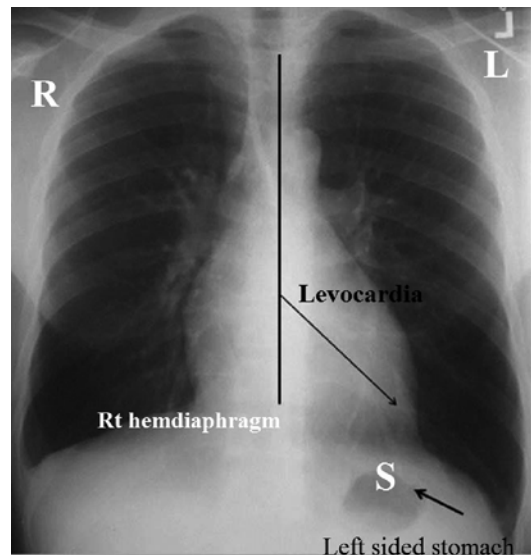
Cardiac location, base-to-apex axis, and positions of the liver and stomach can be determined in the plain chest X-ray. S stomach
